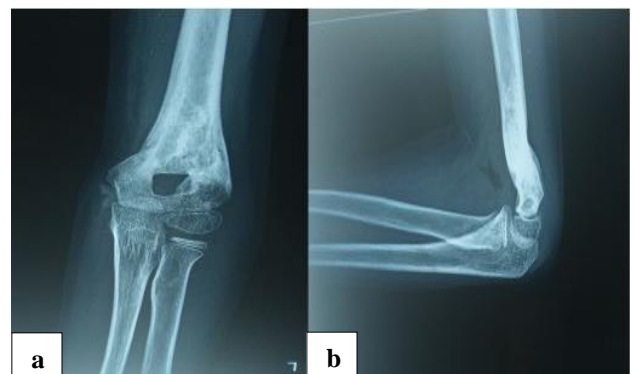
(a and b): 6 months post-operative X-ray.
